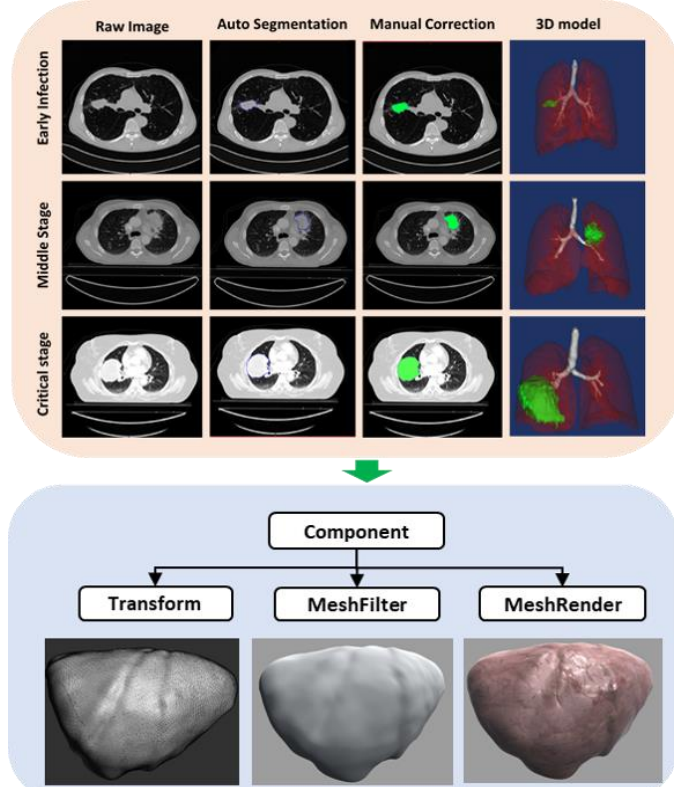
Patient-specific digital twin-based CT rendering from the perception layer. The second part shows the MR visual-haptic reconstruction with medical data.
